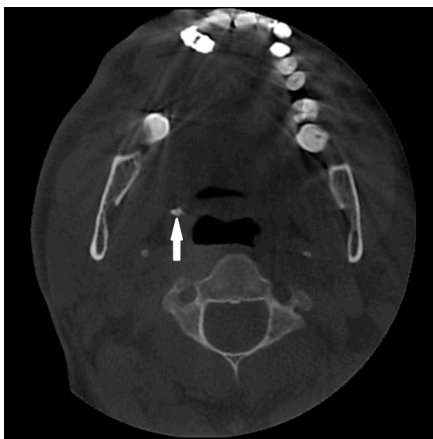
Axial CBCT image of a tonsillolith (arrow).
